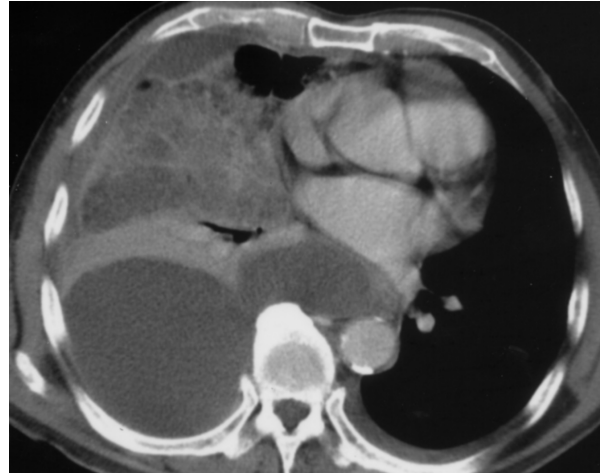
Computed tomography (CT) showing right thoracic empyema.
